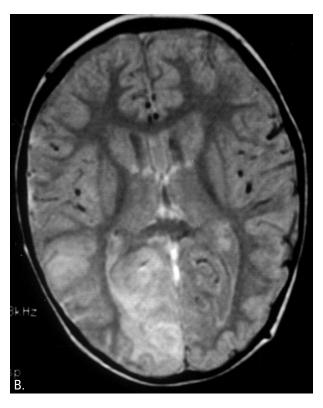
Brain imaging in acute stroke A) hemorrhage (CT) B) 'reversible posterior leukoencephalopathy' (MRI) C) occipital infarction in sinovenous thrombosis (MRI) D) basal ganglia infarction associated with 'transient cerebral arteriopathy' stenosis (MRI) E) widespread infarction after recurrent stroke (MRI) F) bilateral frontal infarction in moyamoya.
